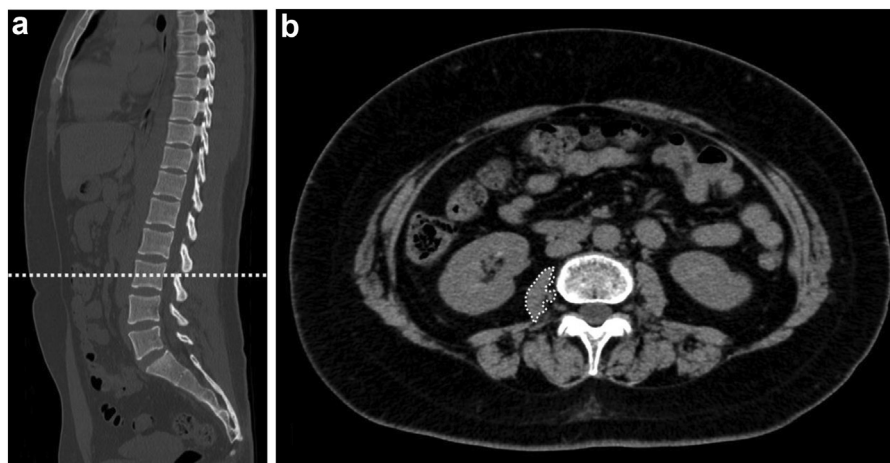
Measurement of the quantity and quality of the psoas major muscle. (a) Psoas muscle index (PMI) and radiation density (RD) were measured at the mid-level of the L3 vertebra. (b) The cross-sectional area and average computed tomography (CT) values (RD) in the psoas major muscle (dotted lines) were calculated. The figure shows a CT image taken before total hip arthroplasty on the right side.
